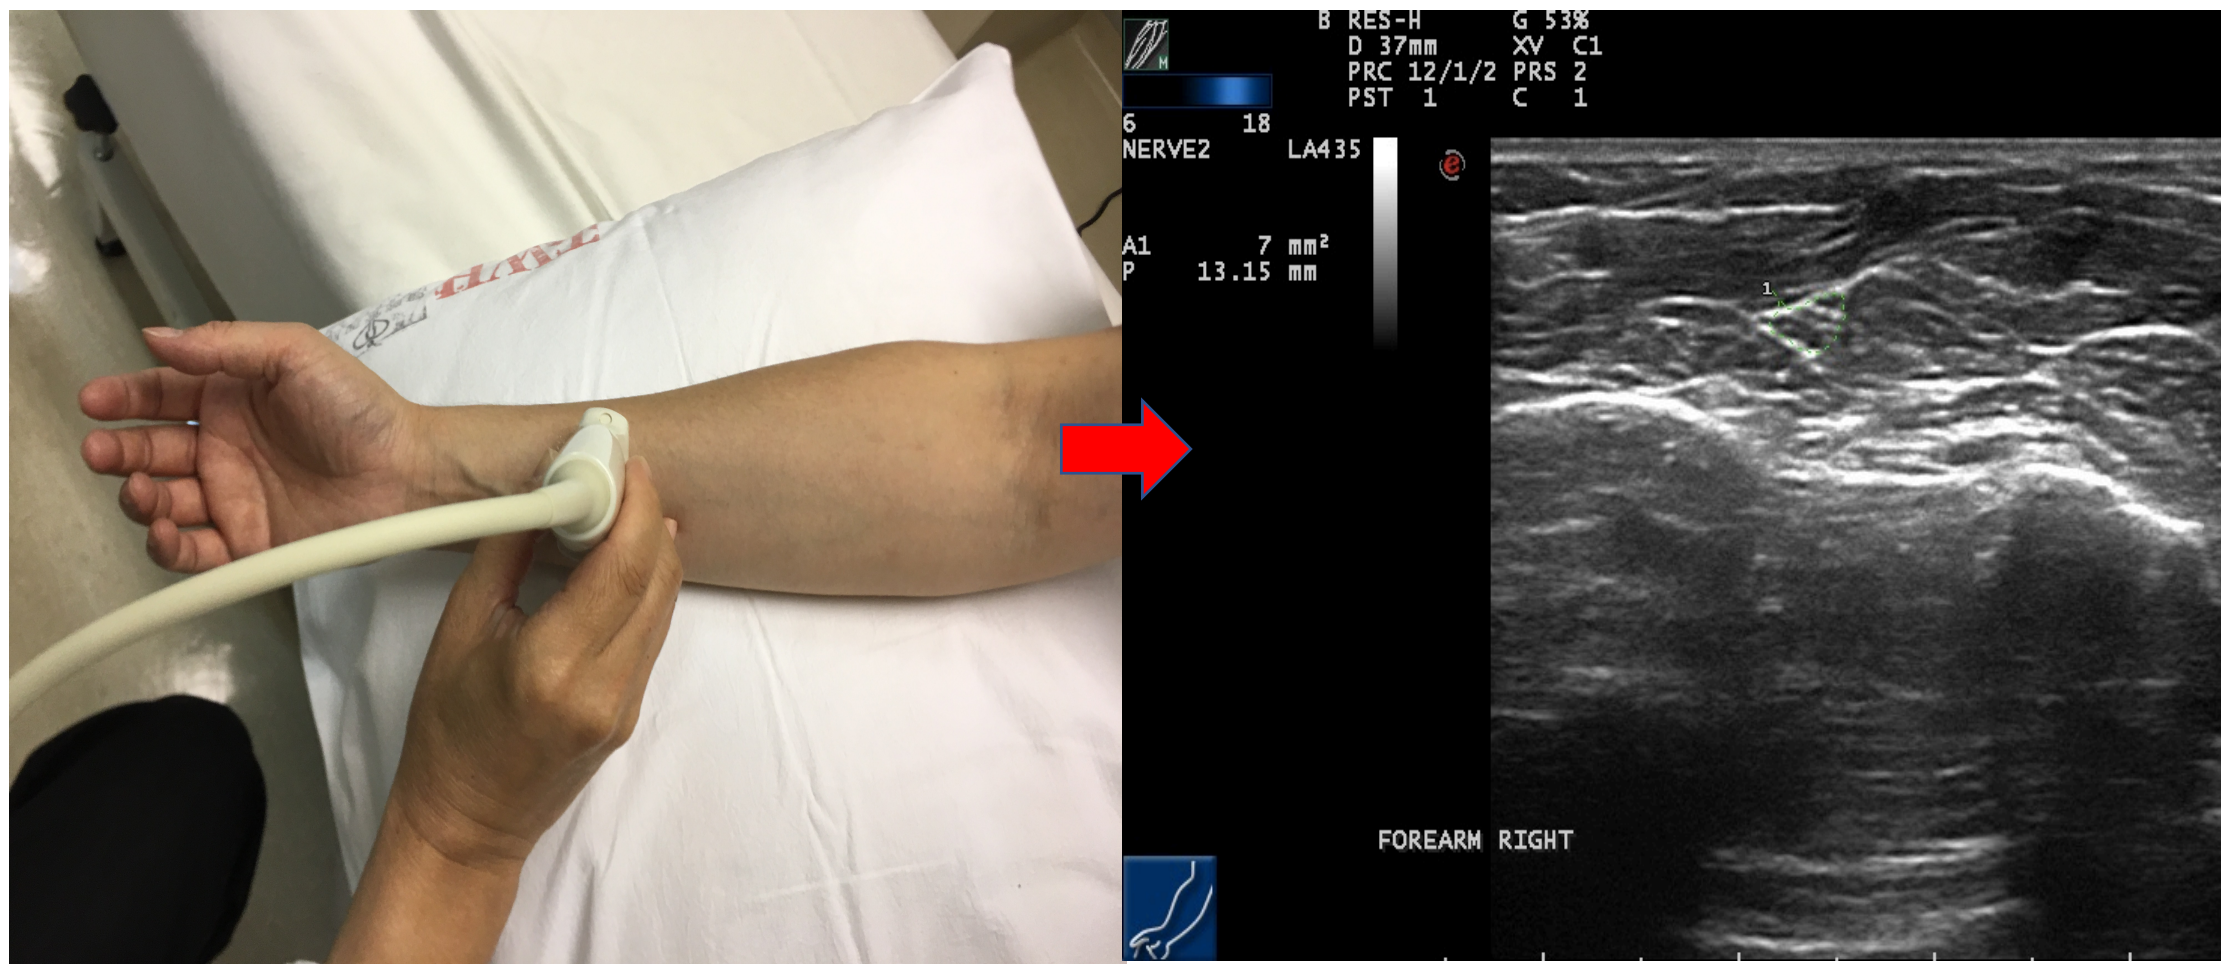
Measurement of the distal one-third forearm and its ultrasound imaging
